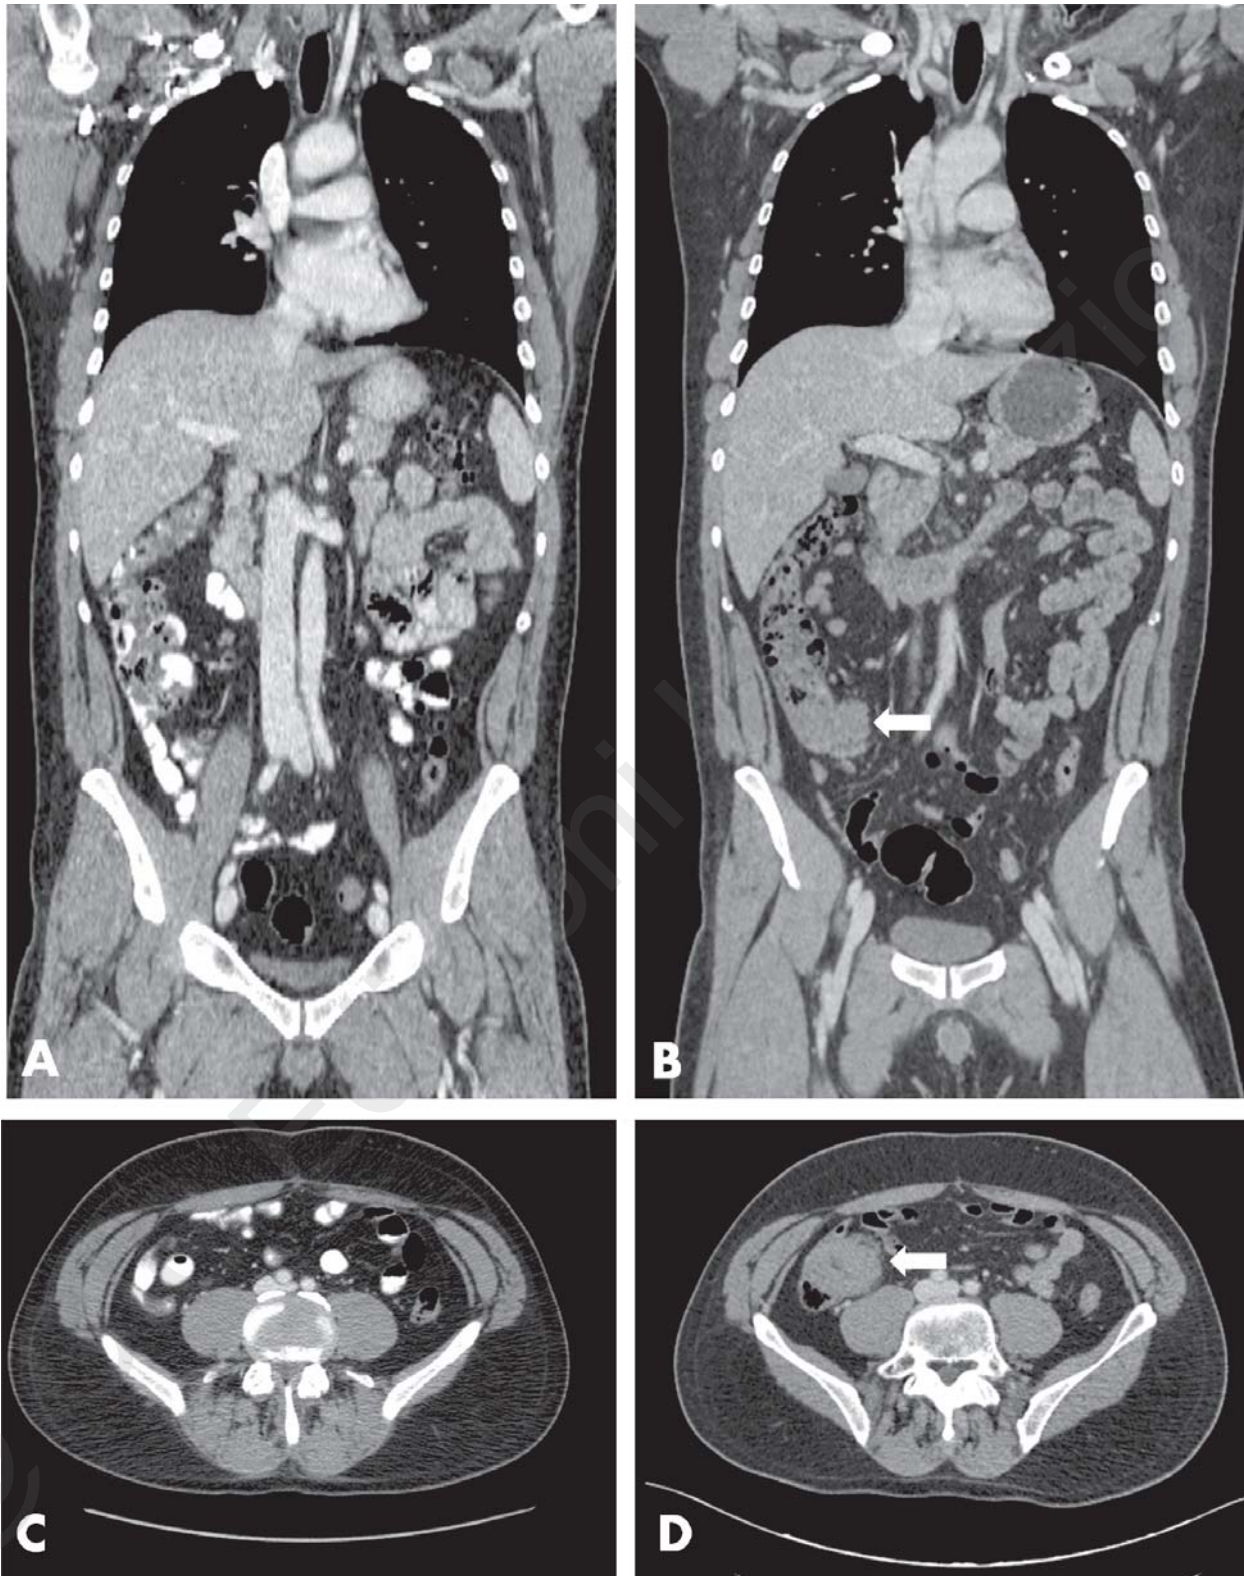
Caecal mass on contrast enhanced CT. Contrast enhanced CT performed after the WB-MRI scan (B, D) confirmed the presence of the caecal mass (white arrow) which was absent in the CT scan performed one year before (A, C). Contrast enhanced CT demonstrated a well-defined mass with slight and homogeneous enhancement after administration of intravenous contrast agent; the mucosal layer covering the mass was intact and the fat plane surrounding the lesion was preserved. All these characteristics suggested that the mass was exophytic and arisen from the submucosal layer of the caecum.
